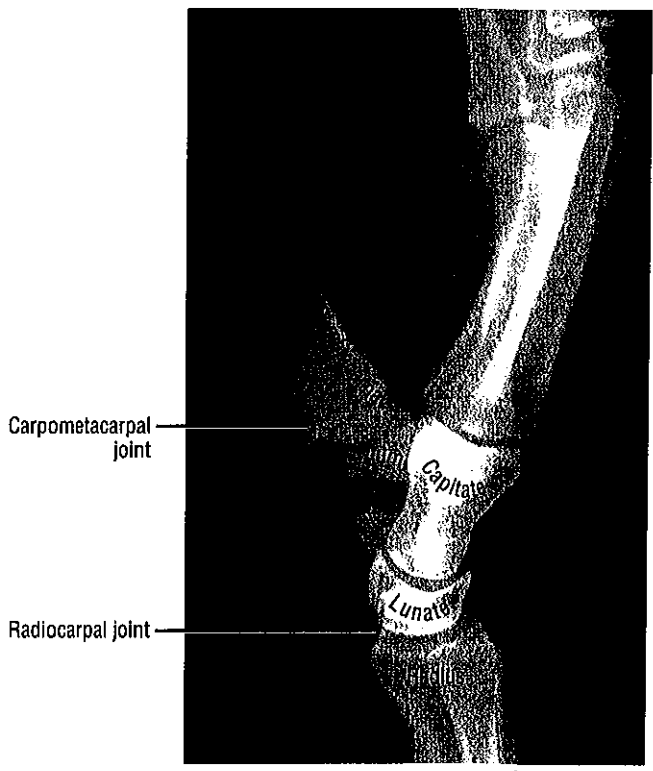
A lateral x-ray with an emphasis on the palmar projection of the thumb (first metacarpal), scaphoid, and trapezium. Note the contrast in the spatial orientation of the capitate and other metacarpal bones.
